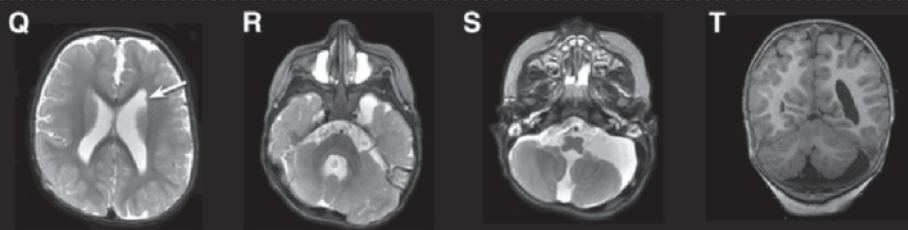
Representative MRI images from females 1, 2, 3, 7, and 16 with de novo *USP9X* loss-of-function mutations.
